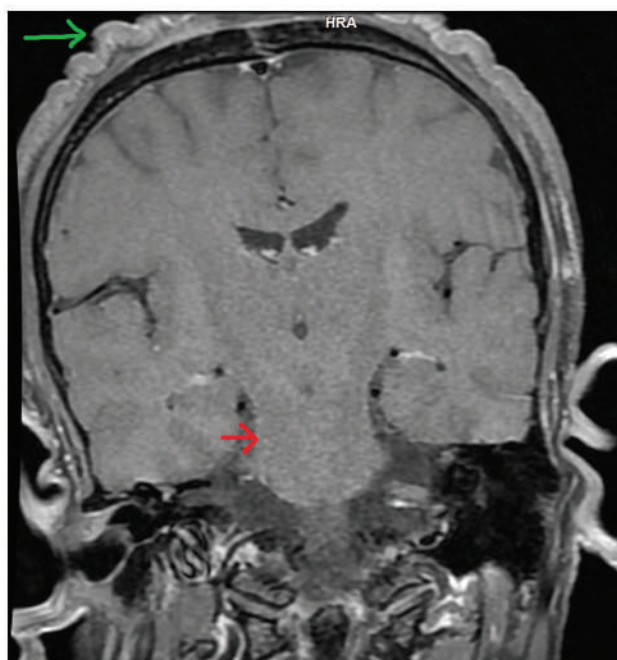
MRI brain coronal section showing pituitary macroadenoma (red arrow) and cutis verticis gyrata (green arrow).
